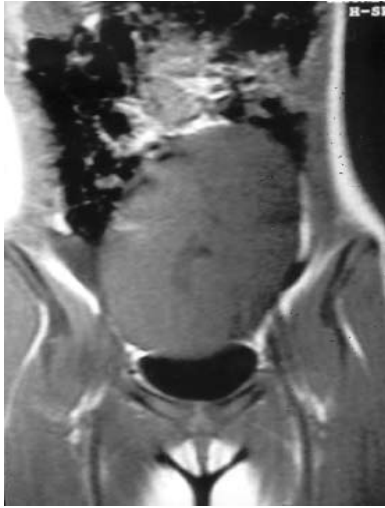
Coronal T1-weighted magnetic resonance image of the pelvis showing the wandering spleen.
